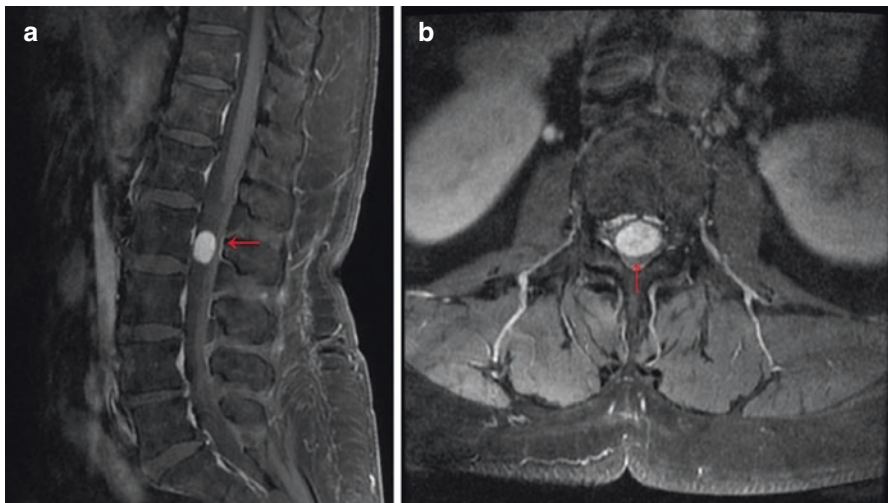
Lumbar spine MRI with contrast showing enhancing intradural extramedullary lesion 11 mm × 17 mm × 15 mm at L2 vertebral body level consistent with Schwannoma. (a) Midline sagittal view of T1-weighted with contrast. (b) Axial view of T1-weighted with contrast at L2 vertebral body level
